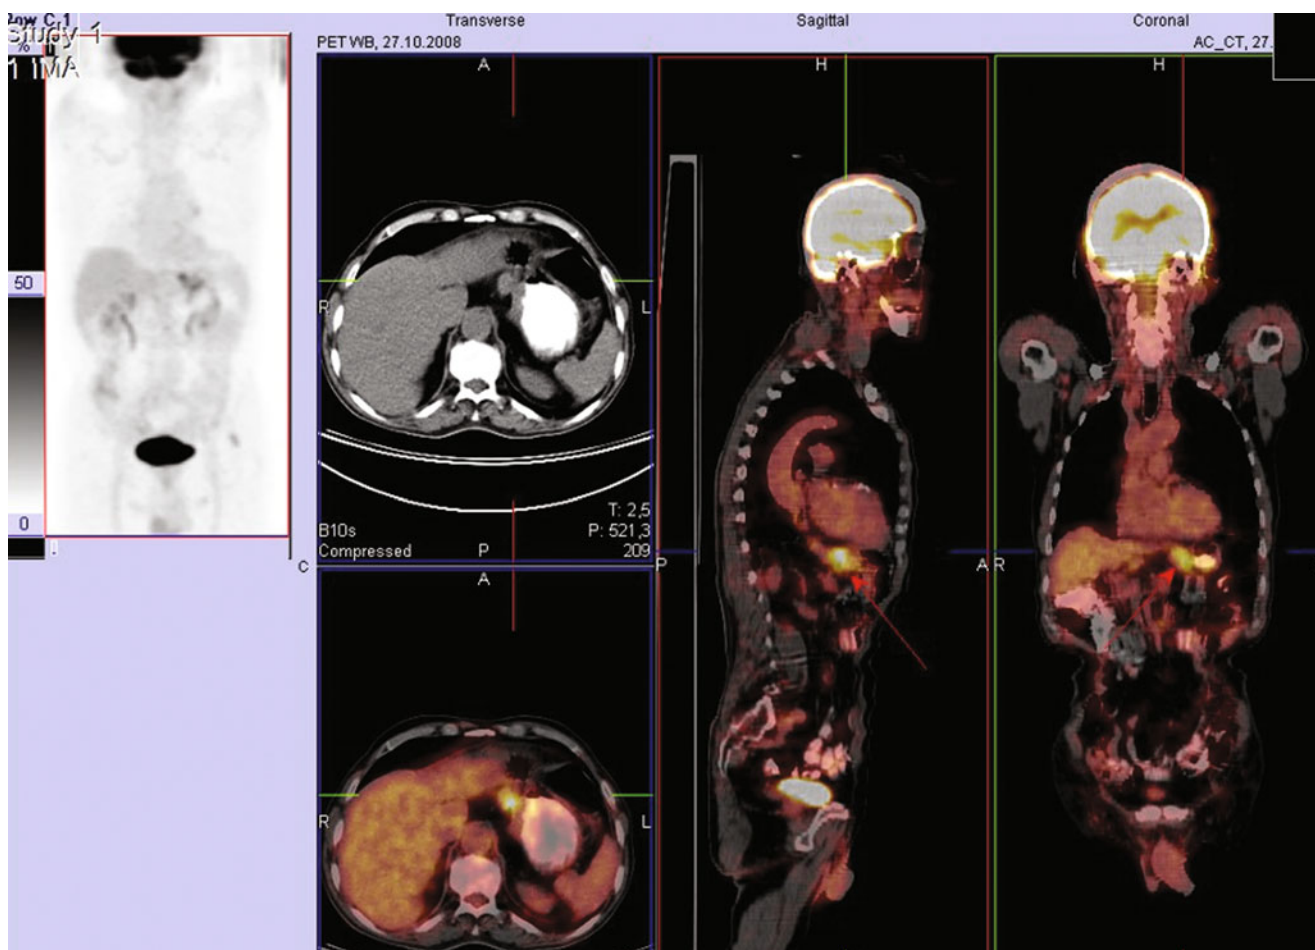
FDG PET/CT images in a 72-year-old man with gastric cancer. The scan was carried out because of the suspicion of distant metastasis at diagnostic CT and an increase in tumour markers. The images show
